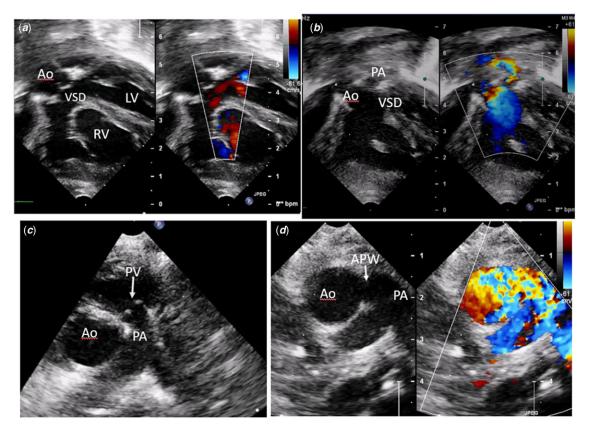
(a): Subcostal view showing large ventricular septal defect (VSD) with 50% aortic (Ao) override. (b): Subcostal right ventricular outflow tract view showing large doubly committed VSD with aorta (Ao) and pulmonary artery (PA) overriding the defect. (c): Parasternal short-axis view showing hypoplastic pulmonary valve (PV) and dilated right and left pulmonary arteries (RPA, LPA). (d): Parasternal short-axis view showing large aortopulmonary window (APW) from ascending aorta to right pulmonary artery. LV: left ventricle, RV right ventricle.
